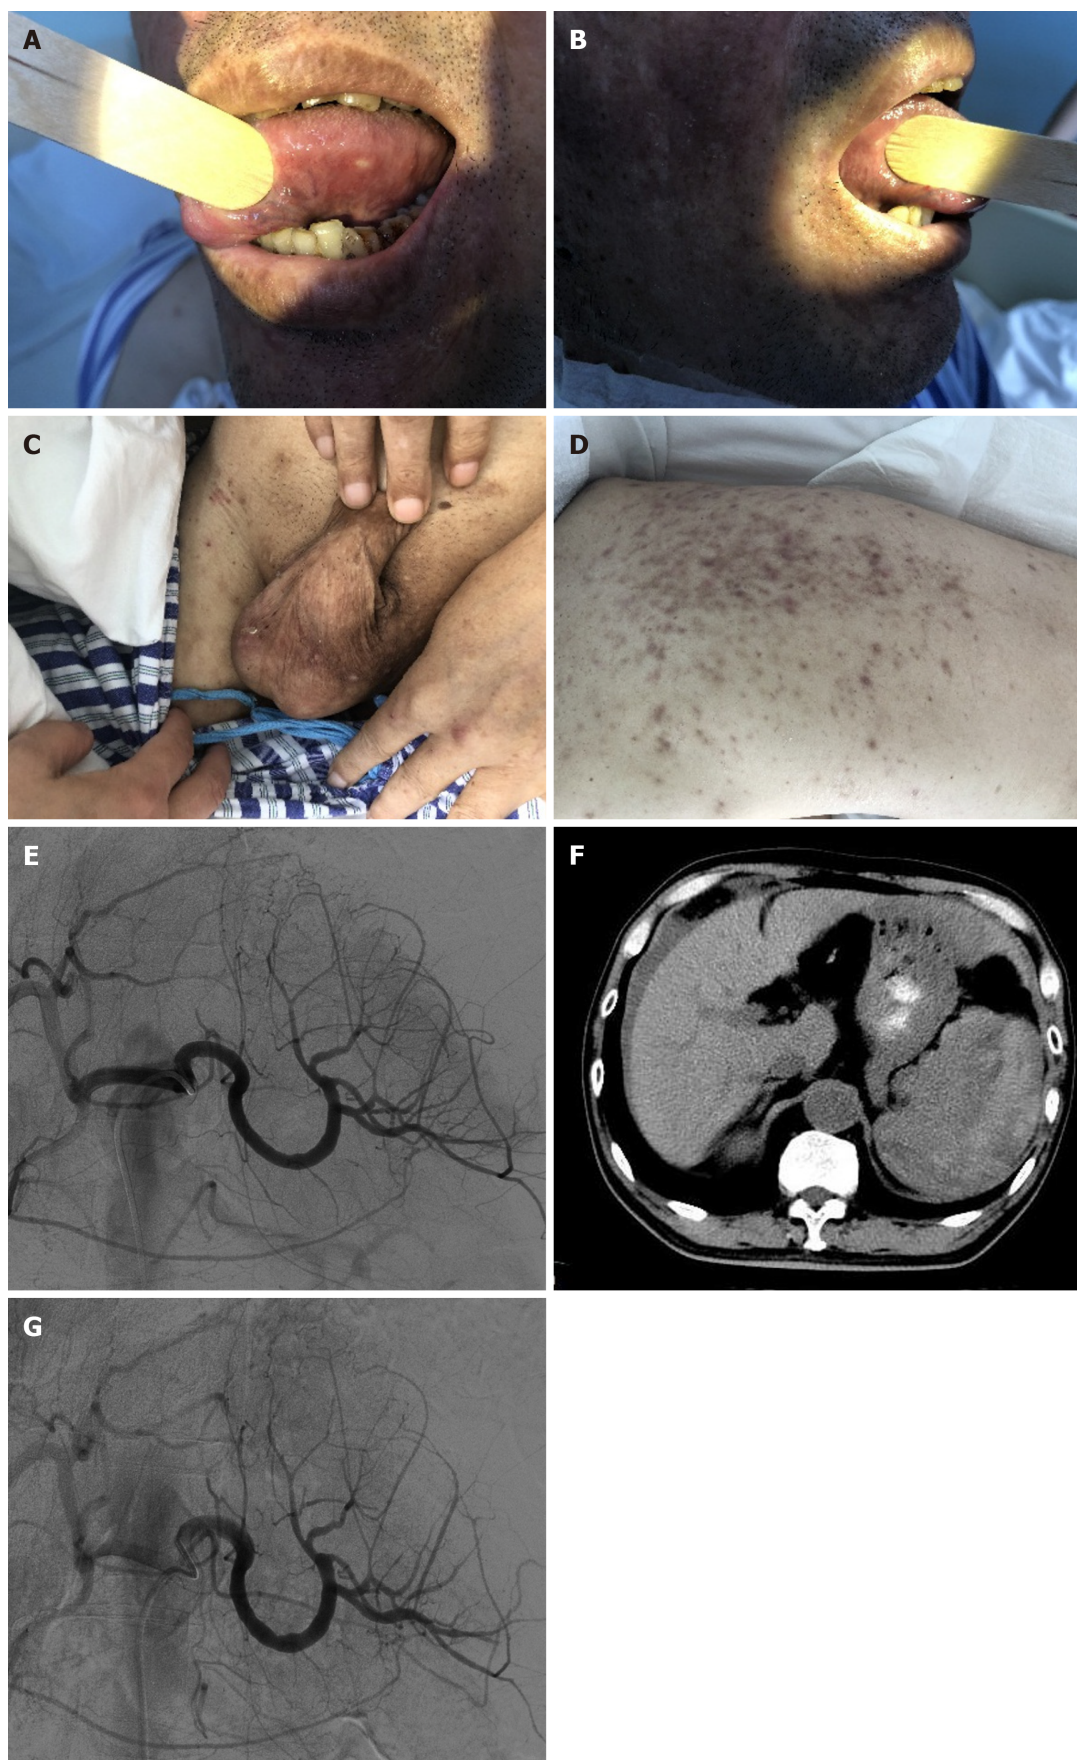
Physical and imaging examinations of the patient. A-D: Multiple oral and genital aphthous ulcers were observed, and acne scars were found in the index admission examination; E: The angiography before splenic artery embolization, splenic arteriography did not show clear culprit blood vessels or lesions such as aneurysms or pseudoaneurysms; F: Computed tomography showed the existence of splenic rupture with a subcapsular hematoma of the spleen; G: Postoperative angiography showed reduced swelling laterally to the spleen.
